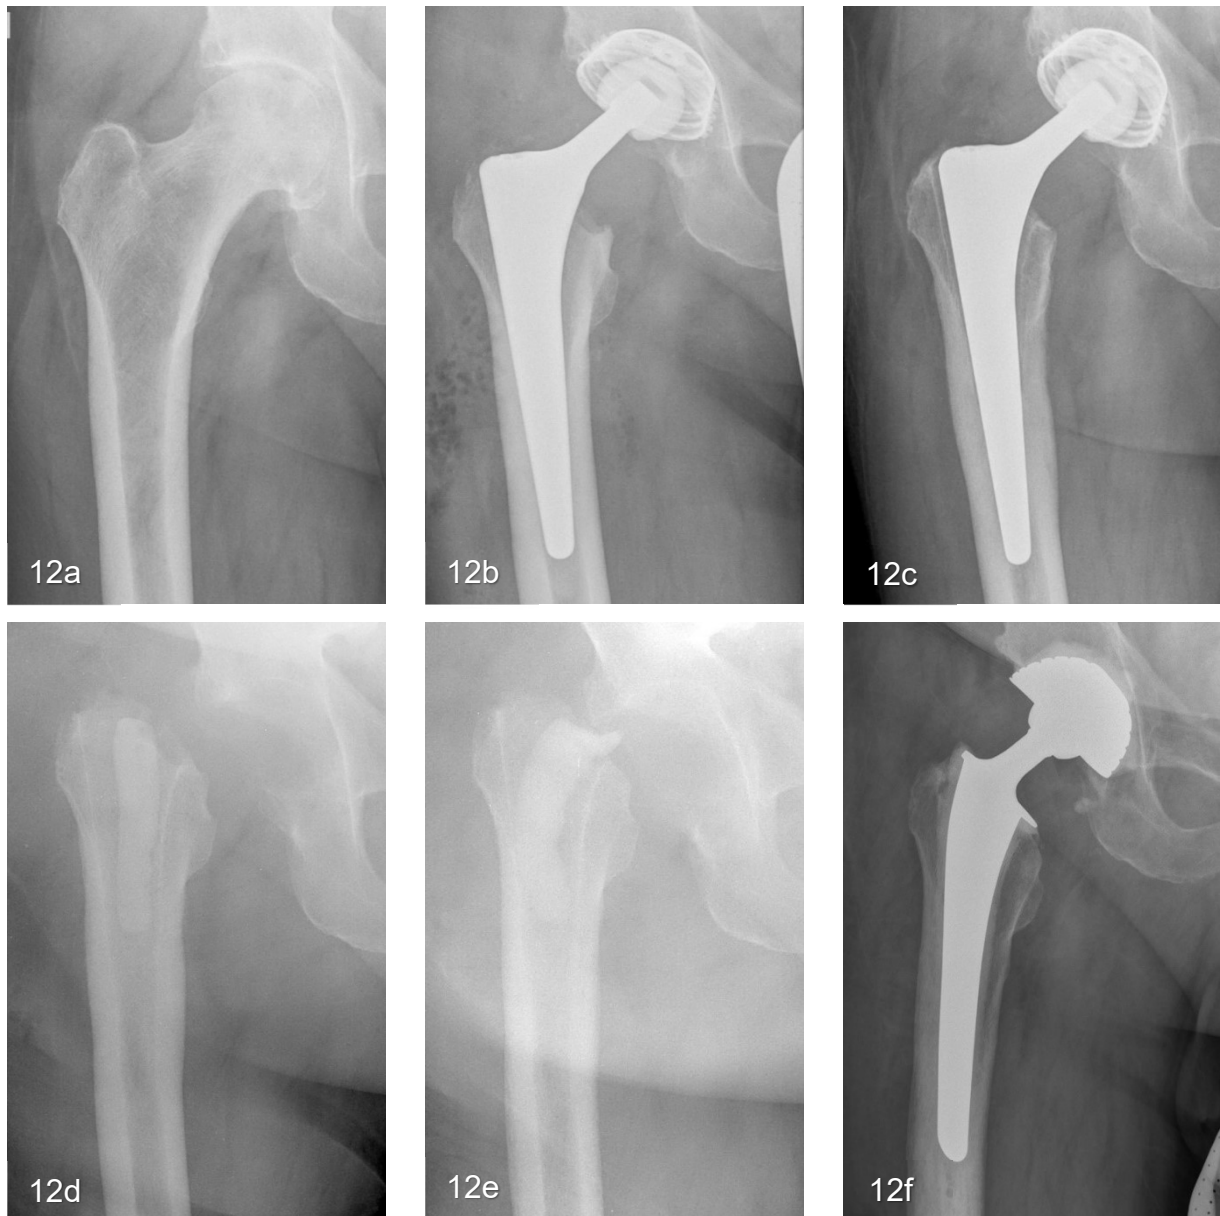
a-f: Radiography of total hip arthroplasty in a 69-year-old patient. a: Before implantation. b: After implantation. c: 11 months after implantation, loosening of the femoral component. d: After explantation, monobloc spacer in situ. e: After spacer exchange because of isolation of *Cutibacterium* by a biopsy after 10 weeks of spacer in situ. f: After reimplantation of a cemented total-hip arthroplasty.
